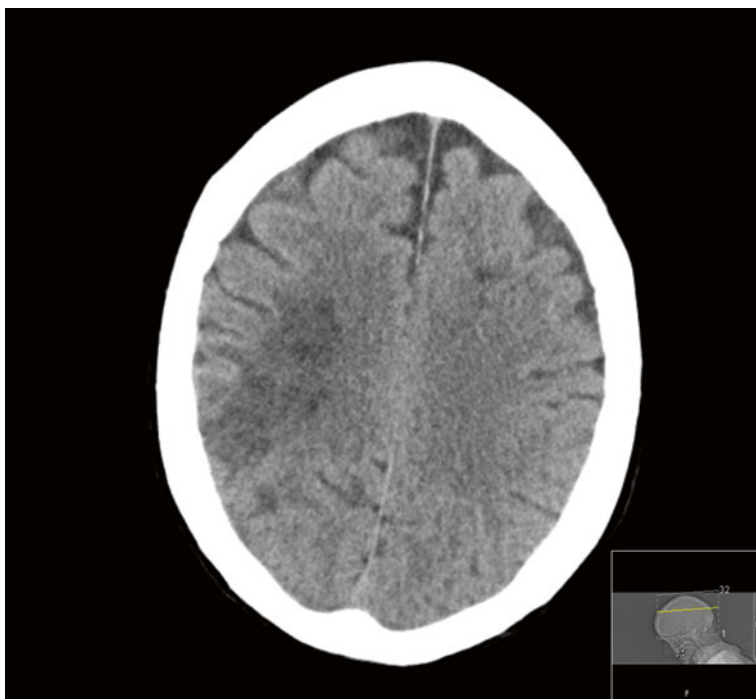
CT brain, axial view. Right middle cerebral artery (MCA) ischaemic stroke
